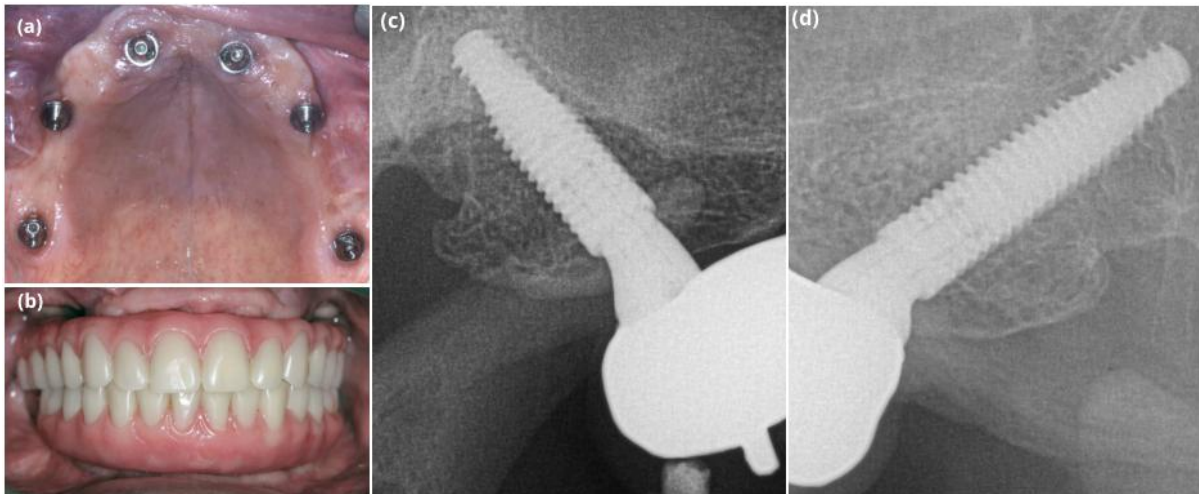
Sixty-month follow-up. Clinical occlusal view (a). Buccal view of the final prostheses (b). Periapical radiographs of the #17 and #27 regions (c-d).
